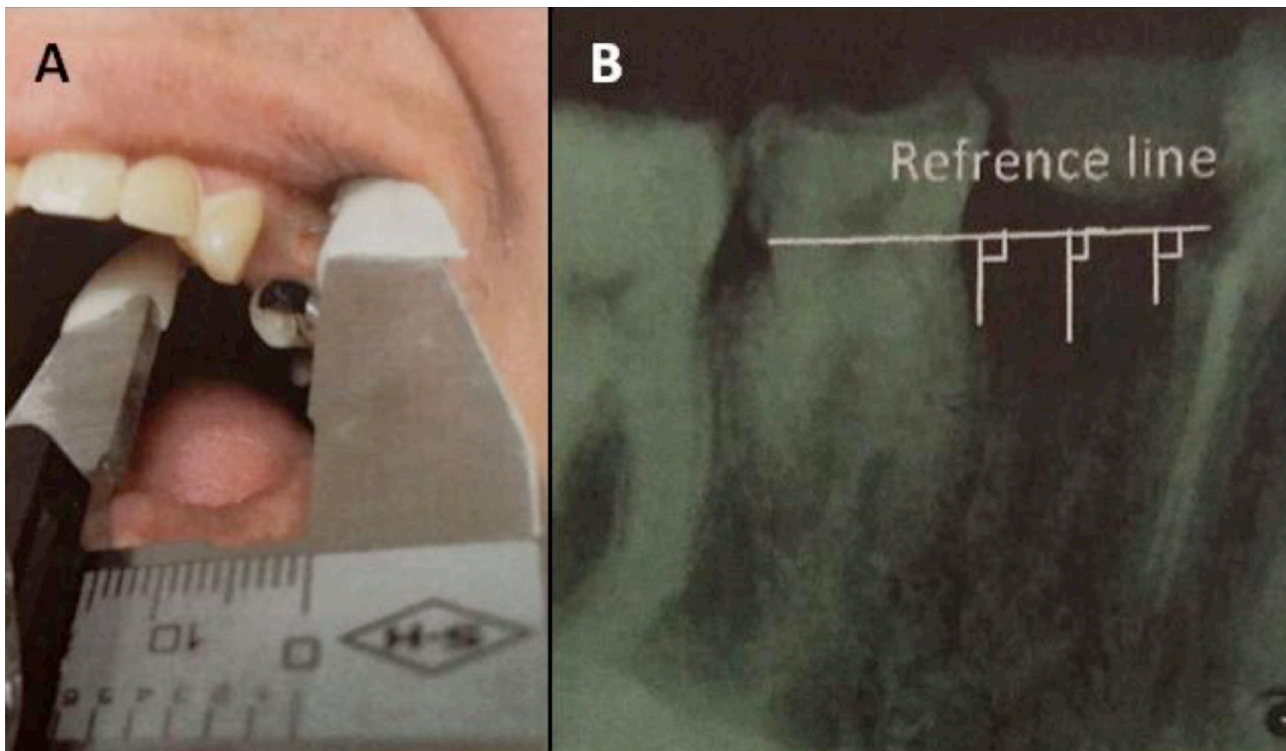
Width and height of the ridge were measured using a digital caliper (A) and parallel intraoral radiograph (B), respectively.
